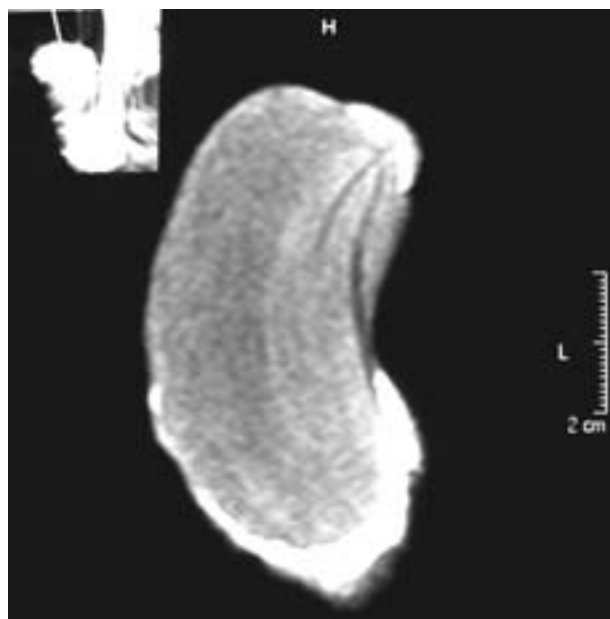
Magnetic resonance imaging shows a penile mass with involvement of the cavernous bodies (T1 weighted imaging).
